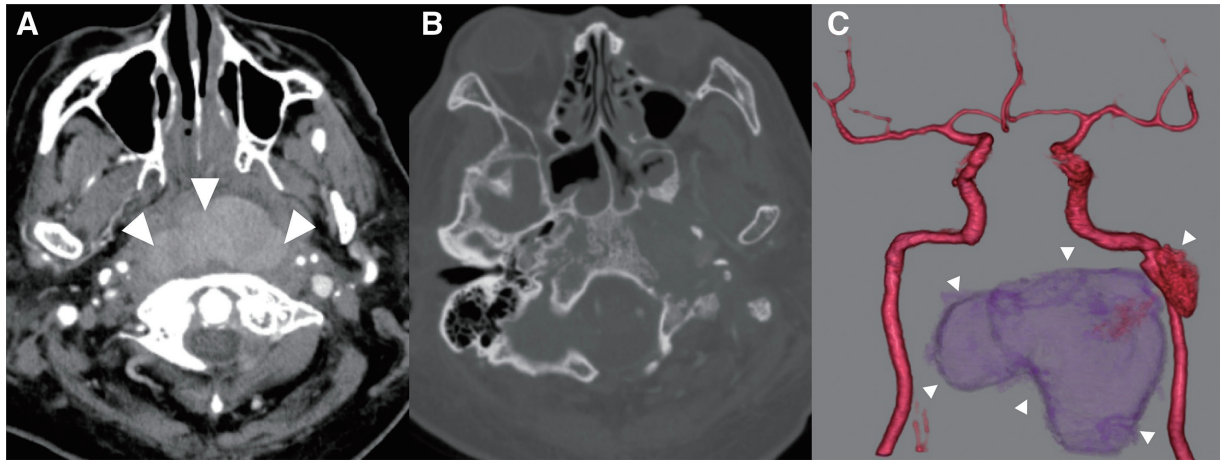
CT on admission. (A) Axial CT scan showing a large mass (arrowhead) with contrast enhancement in the upper and middle pharynx at admission. (B) Axial bone imaging from the CT scan showing osteolysis of the left petrous bone. (C) CT angiogram showing the formation of a pseudoaneurysm (arrowhead) in the petrous segment of the left internal carotid artery.
